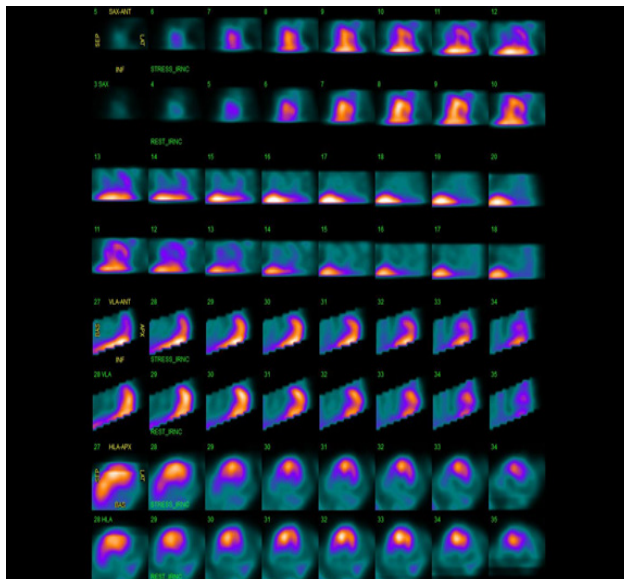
SPECT images showing the stress and rest images in short axis (SA), vertical long axis (VLA), and horizontal long axis (HLA) views. The first row of images show moderate to severe reduction of tracer activity in the basal to apical inferior/inferolateral segments. This was persistent on rest images.
